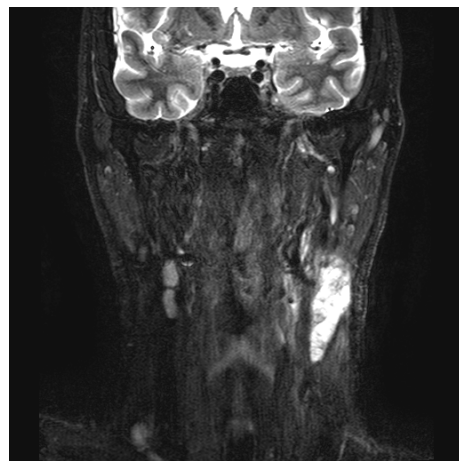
Coronary T2 MRI tomogram with fat suppression shows the presence of conglomerates of necrotic lymph nodes altered by metastasis on the left side of the neck in planocellular carcinoma of the root of the tongue (findings confirmed by PH analysis).
